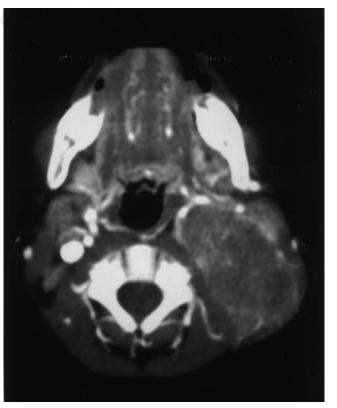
CT image of cervical neuroblastoma causing Horner's syndrome. Tumor was only partially resected to avoid damage to brachial plexus. Residual tumor spontaneously regressed but Horner's syndrome was still present 8+ y later.
